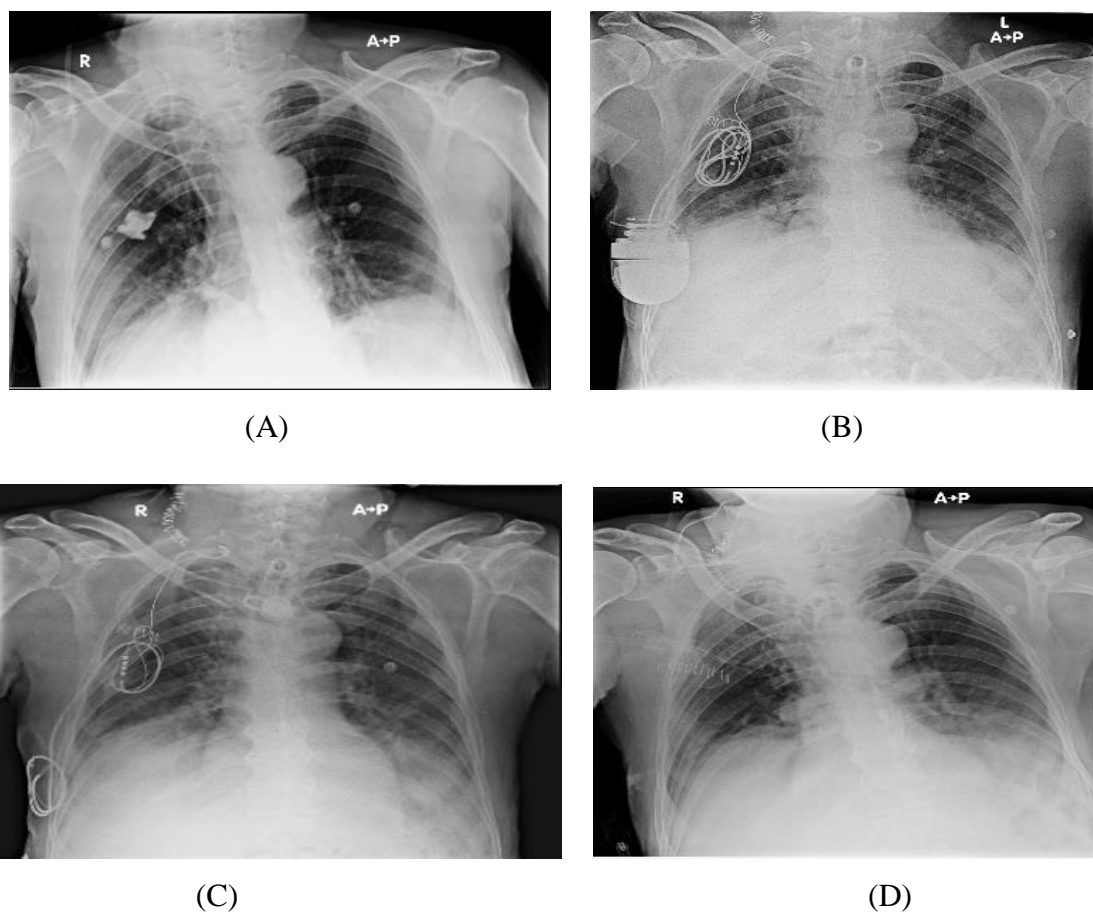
X-Ray chest AP view shows.
